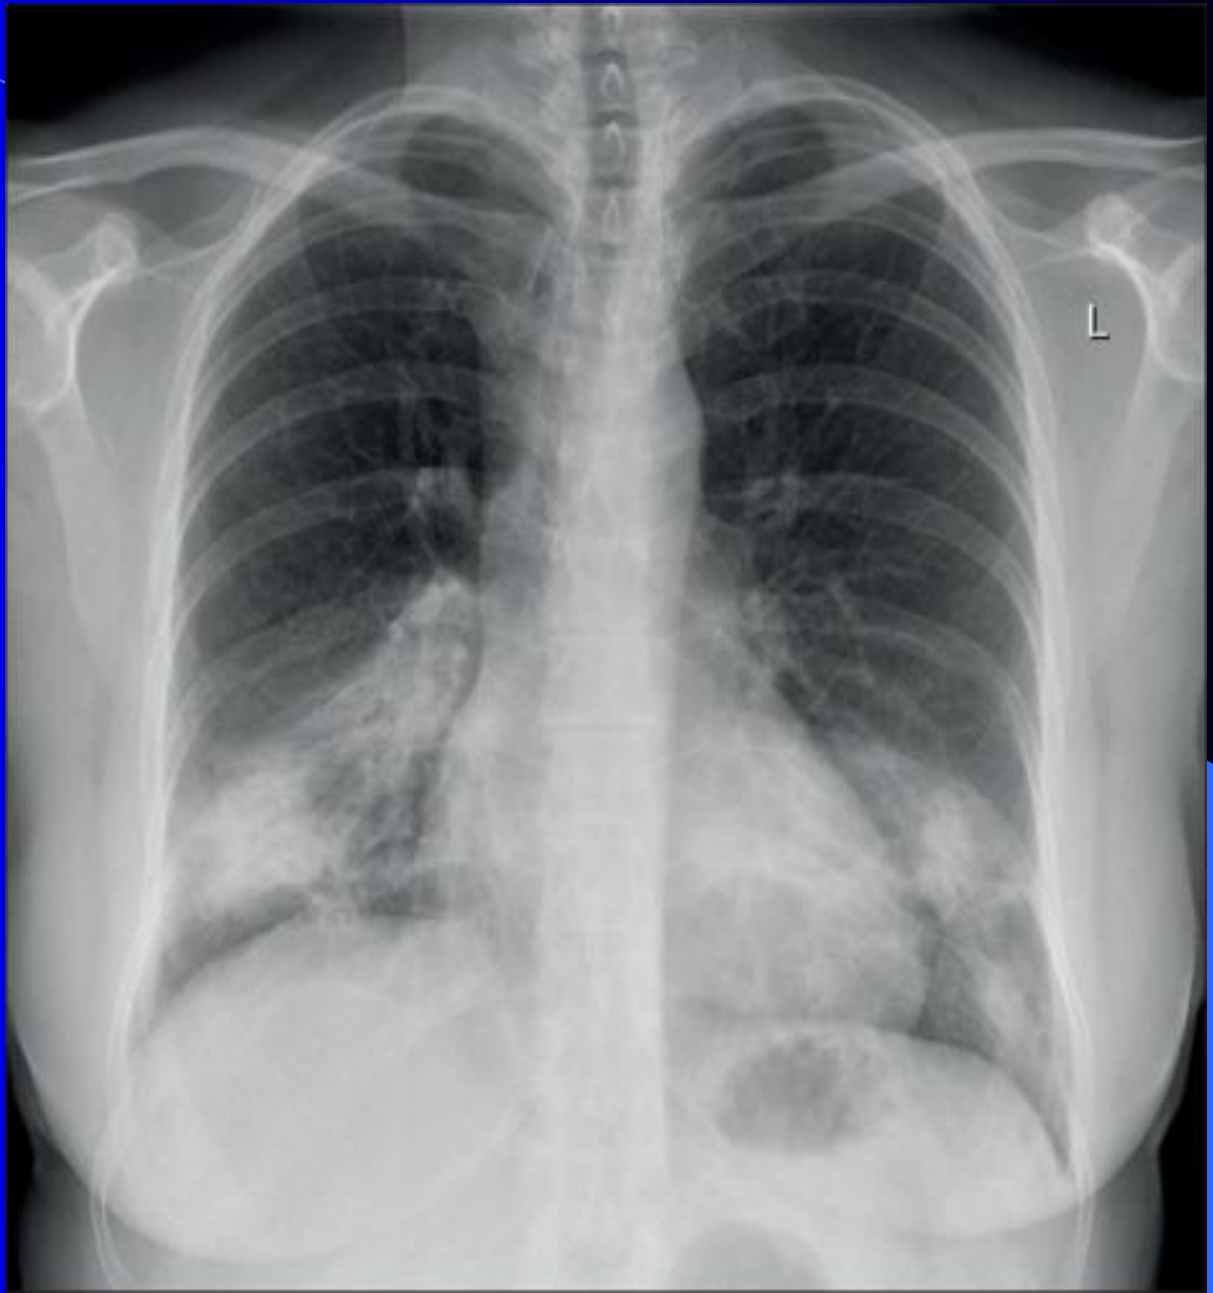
Chest X-ray showing a large, well-defined, rounded opacity in the right lung field, consistent with a pulmonary nodule or mass. The opacity is located in the lower lung zone, approximately at the level of the T10-T11 vertebral level. The rest of the lung fields appear relatively clear, and the mediastinal structures are within normal limits.
